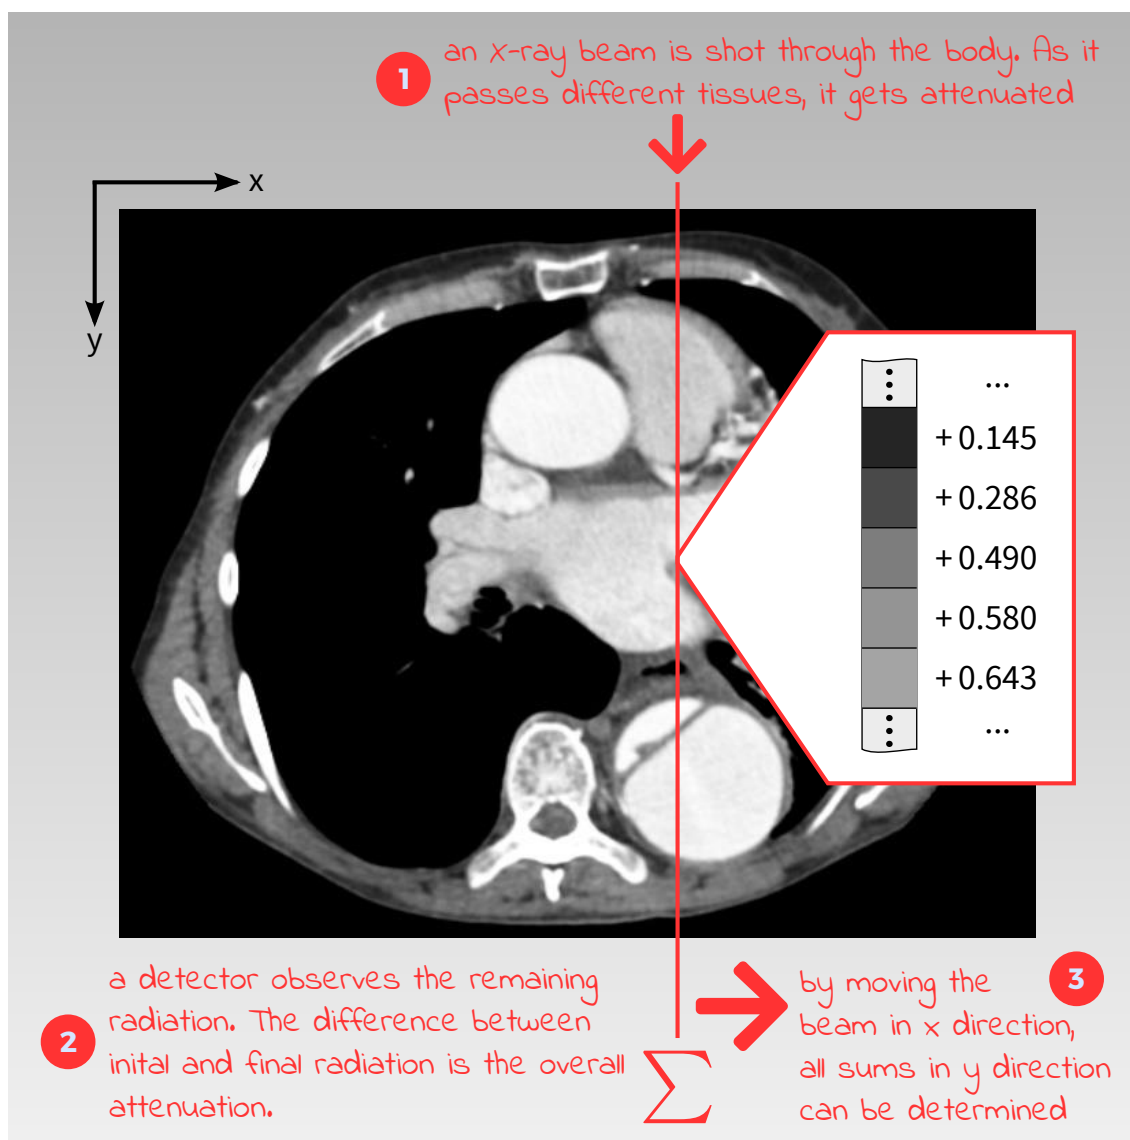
An X-ray beam is shot through the body. As it passes the body, it gets attenuated. The remaining intensity is captured by a detector.
